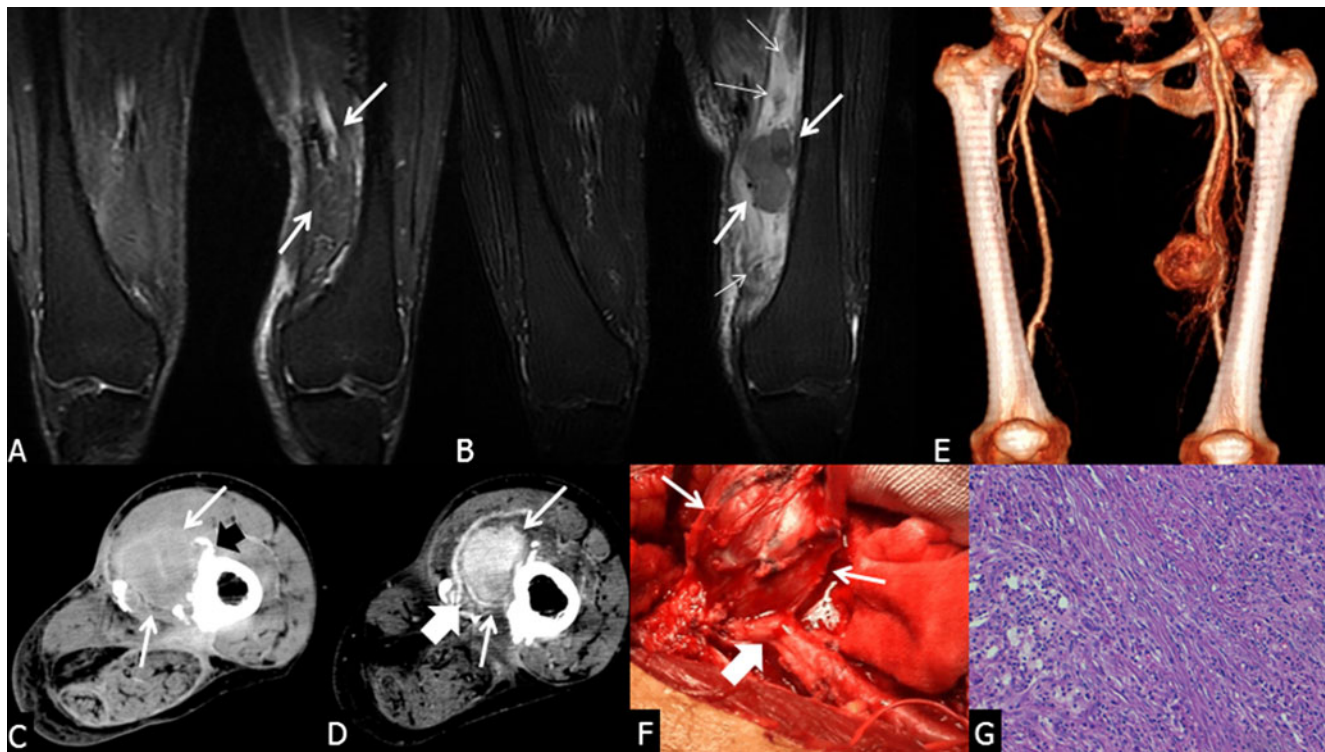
IMT of left thigh in a patient previously treated for lipoma-like liposarcoma. a MR coronal FSE T2-weighted fat-saturated image performed after surgical treatment of lipoma-like liposarcoma shows the absence of space-occupying lesion (arrows) (see the asymmetric muscle volume of the thighs). b MR coronal FSE T2-weighted fat-saturated image performed 3 years later shows a polylobulated low-signal intensity mass of antero-medial compartment of thigh (arrows); note the presence of wide extent of associated edema of the medial compartment of the thigh (thin arrows). c CT scan shows the mass
